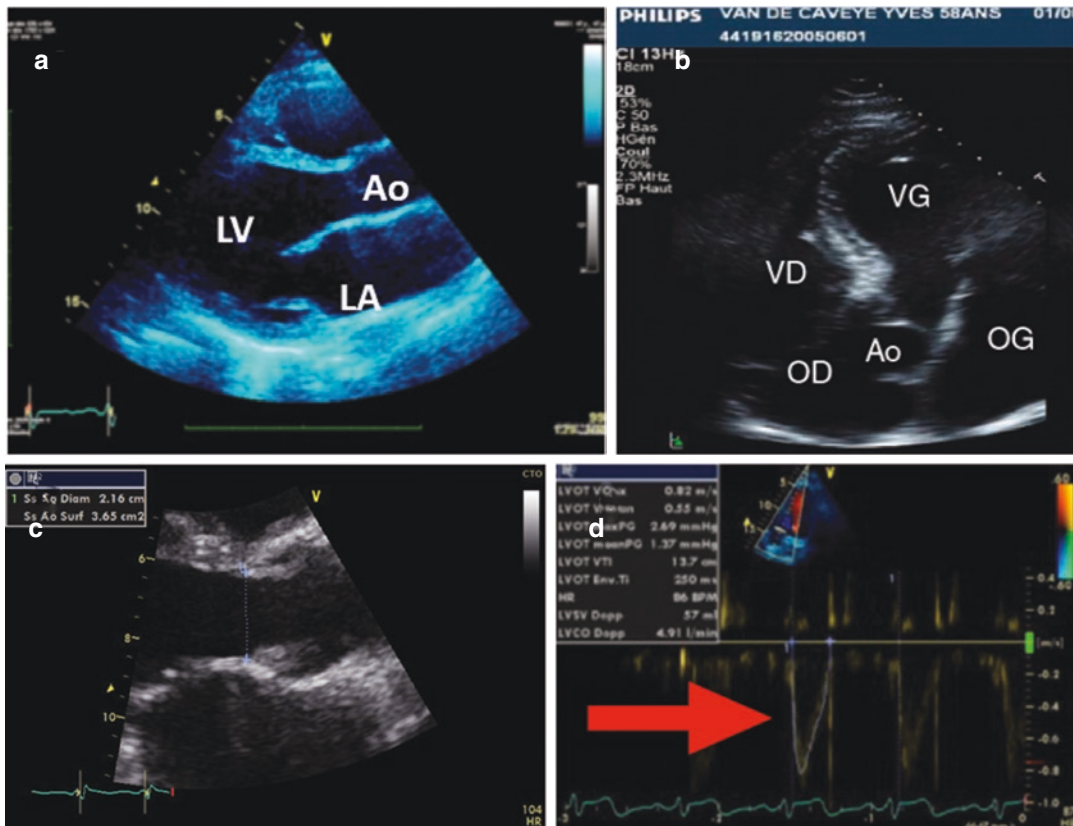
Cardiac output measurement. (a, d) measurement of aortic annulus diameter. (b) Apical 5-chamber view. (c) Aortic annulus measurement from parasternal long axis view focused on the left ventricular outflow tract.
